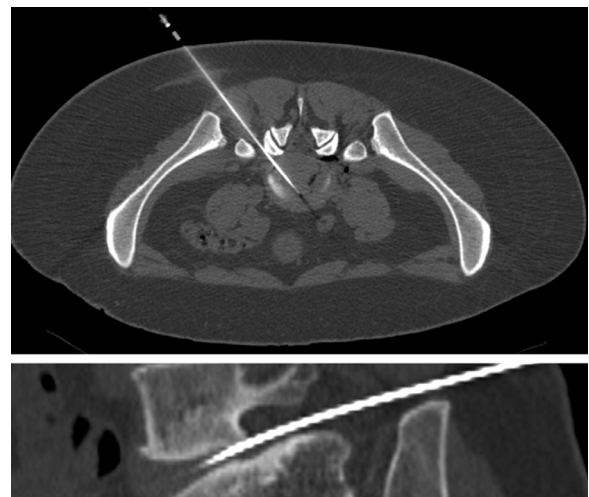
CT-Guided procedure. Axial (upper) and sagittal (lower) cross-sectional scannographic acquisitions showing the position of the needle in the centre of the disc and the gas diffusion after oxygen-ozone mixture injection.
